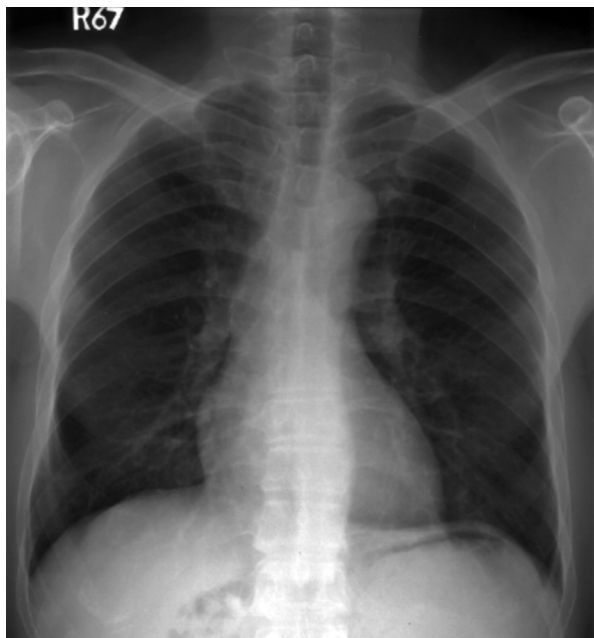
Chest radiograph shows mildly residual reticulo-nodular lesions in bilateral lungs, and still no enlarged hilum.
